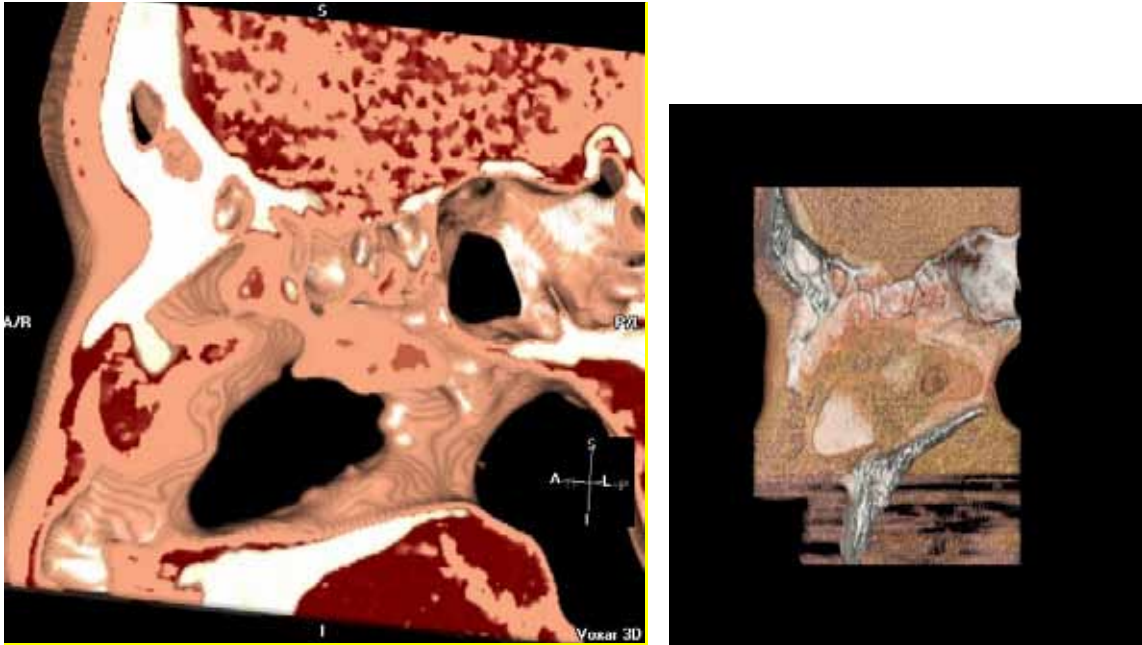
Elaborated CT reconstruction with the method described in the text, and post-operative reconstruction with repair of the perforation. The biological material utilized in reconstruction and repair of the perforation is visible.
